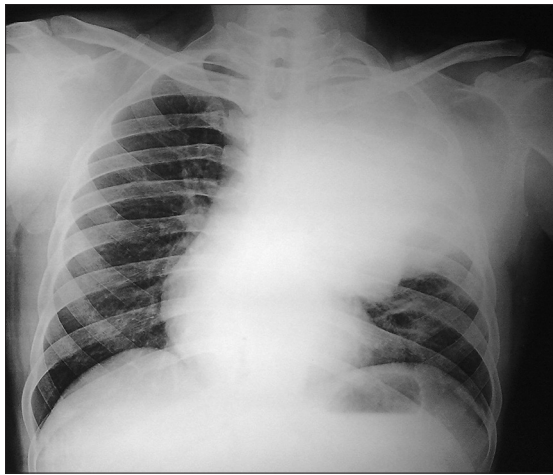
X-ray chest PA view showing left upper lobe mass lesion
